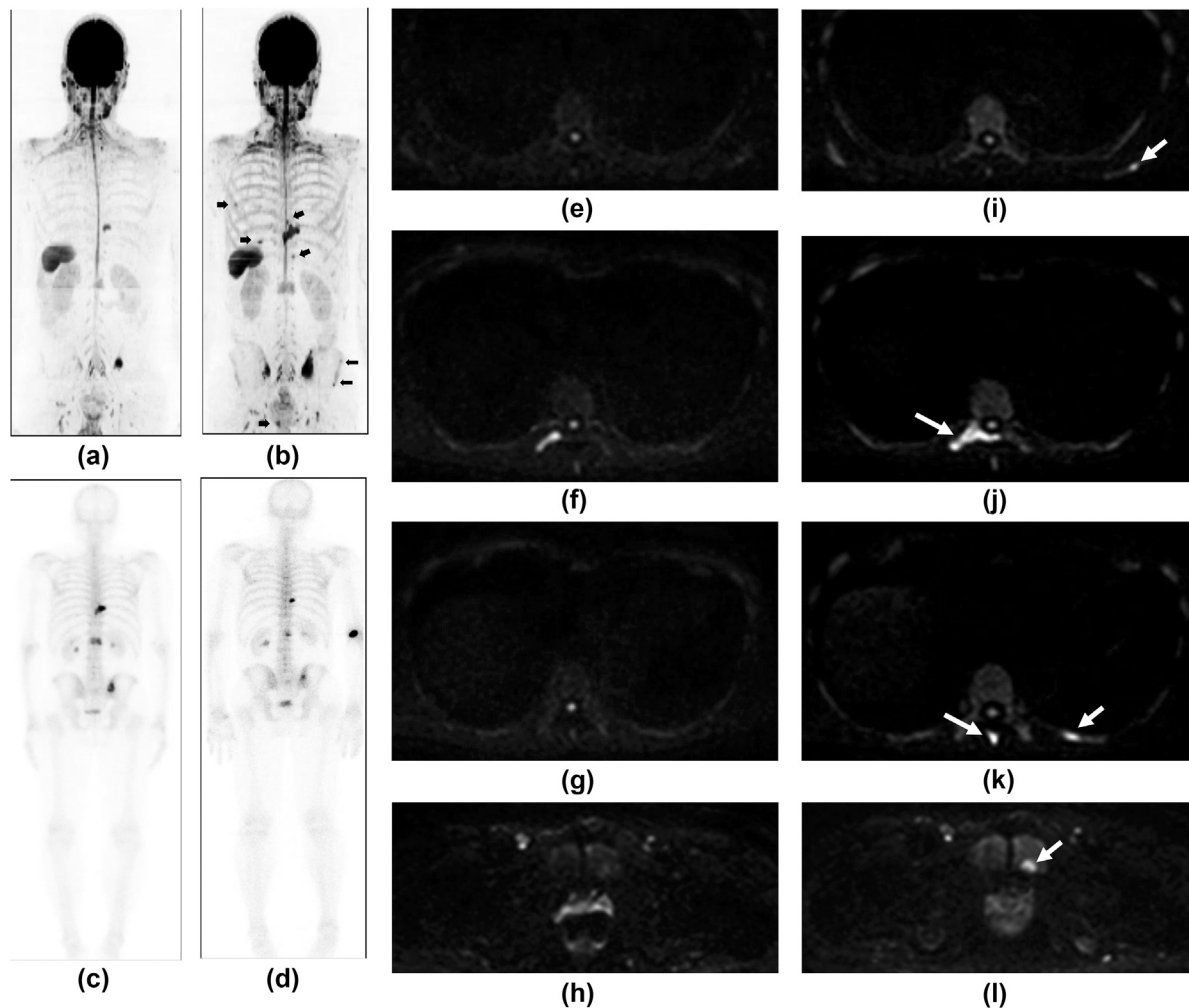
WB-MRI demonstrates progressive metastatic bone disease whilst BS remains stable in a 66-year-old man with bone-only metastatic prostate cancer at baseline and after therapy. (a) Posterior view $b = 900 \text{ s/mm}^2$ MIP at baseline and (b) after 3 months follow-up. (c) BS before and (d) after 3 months follow-up and (e–h) representative axial $b = 900 \text{ s/mm}^2$ DW-MRI before and (i–l) after 3 months follow-up. BS shows now new lesions and therefore no progression by radiological PCWG criteria. PSA rise ($19\text{--}60 \mu\text{g/l}$). MRI shows multiple new bone lesions and significant increase in size of the pre-existent lesions (arrows).
